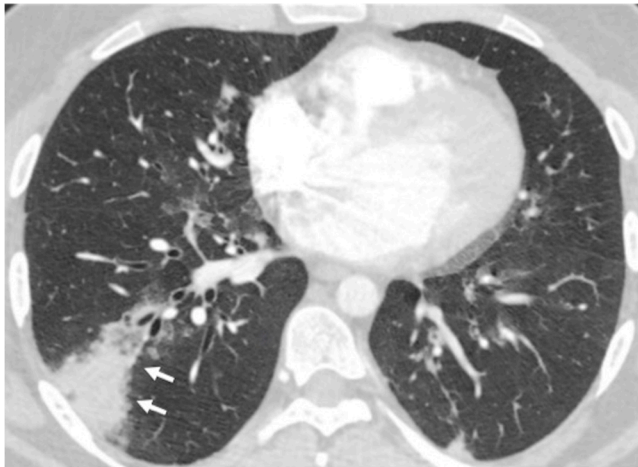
42-year-old male with fever following bone marrow transplantation. Adenovirus was the only pathogen recovered from respiratory secretions. Axial CT image shows segmental consolidation with mild surrounding ground glass in the right lower lobe (arrows). A small subpleural focus of consolidation is also seen.
